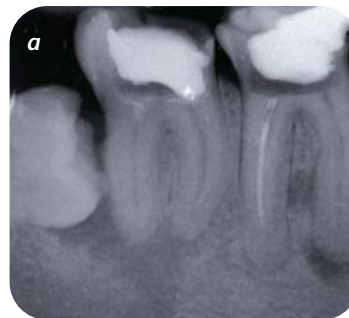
Preoperative periapical radiograph of tooth 47, demonstrating an apical radiolucency indicative of apical periodontitis associated with the 46 and 47. This second molar tooth was considered suitable for the multi-root competence test.
